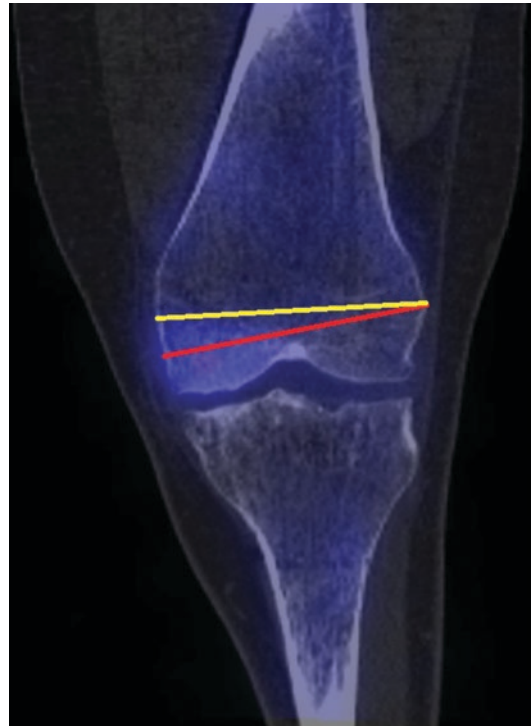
Coronal CT slice with surgical (sTEA) in red and the anatomical (aTEA) transepicondylar axis in yellow
